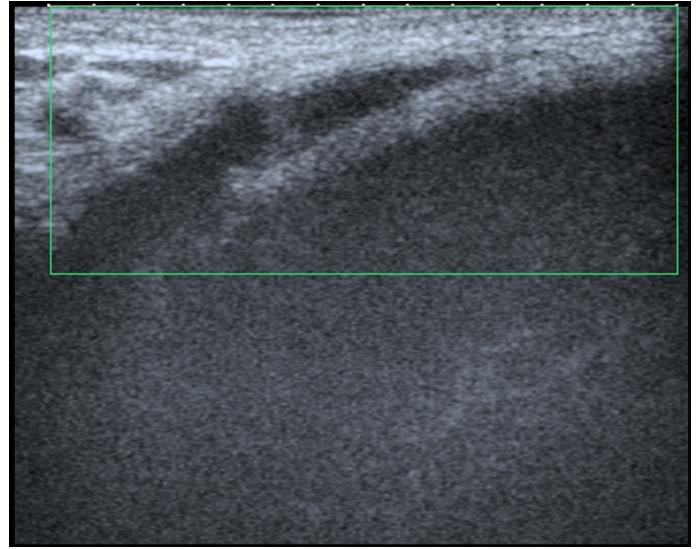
Color Doppler image reveals no color coding in the proximal penile segment of the superficial dorsal penile vein, but real-time gray-scale images (not shown) revealed a very slow blood flow in this venous segment.
